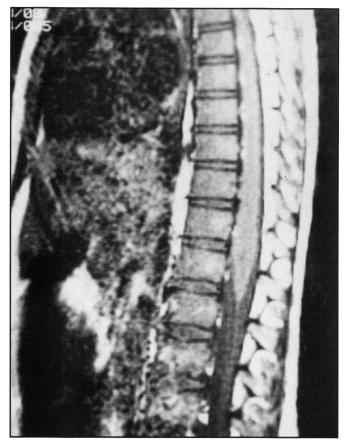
(d) — MRI (TR 500, TE 20) thoracolumbar spine showing diffuse enlargement of spinal cord to the level of the conus.
